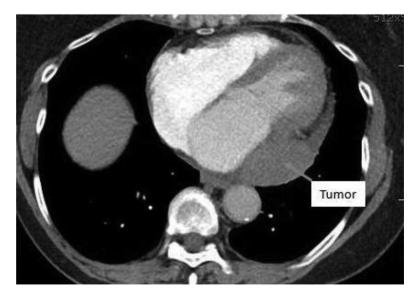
Computed tomography: modified four-chamber view showing well-circumscribed, homogenous mass abutting the left atrium within the confines of pericardium. There appears to be neither intra-atrial or intracardiac nor extracardiac extension.
